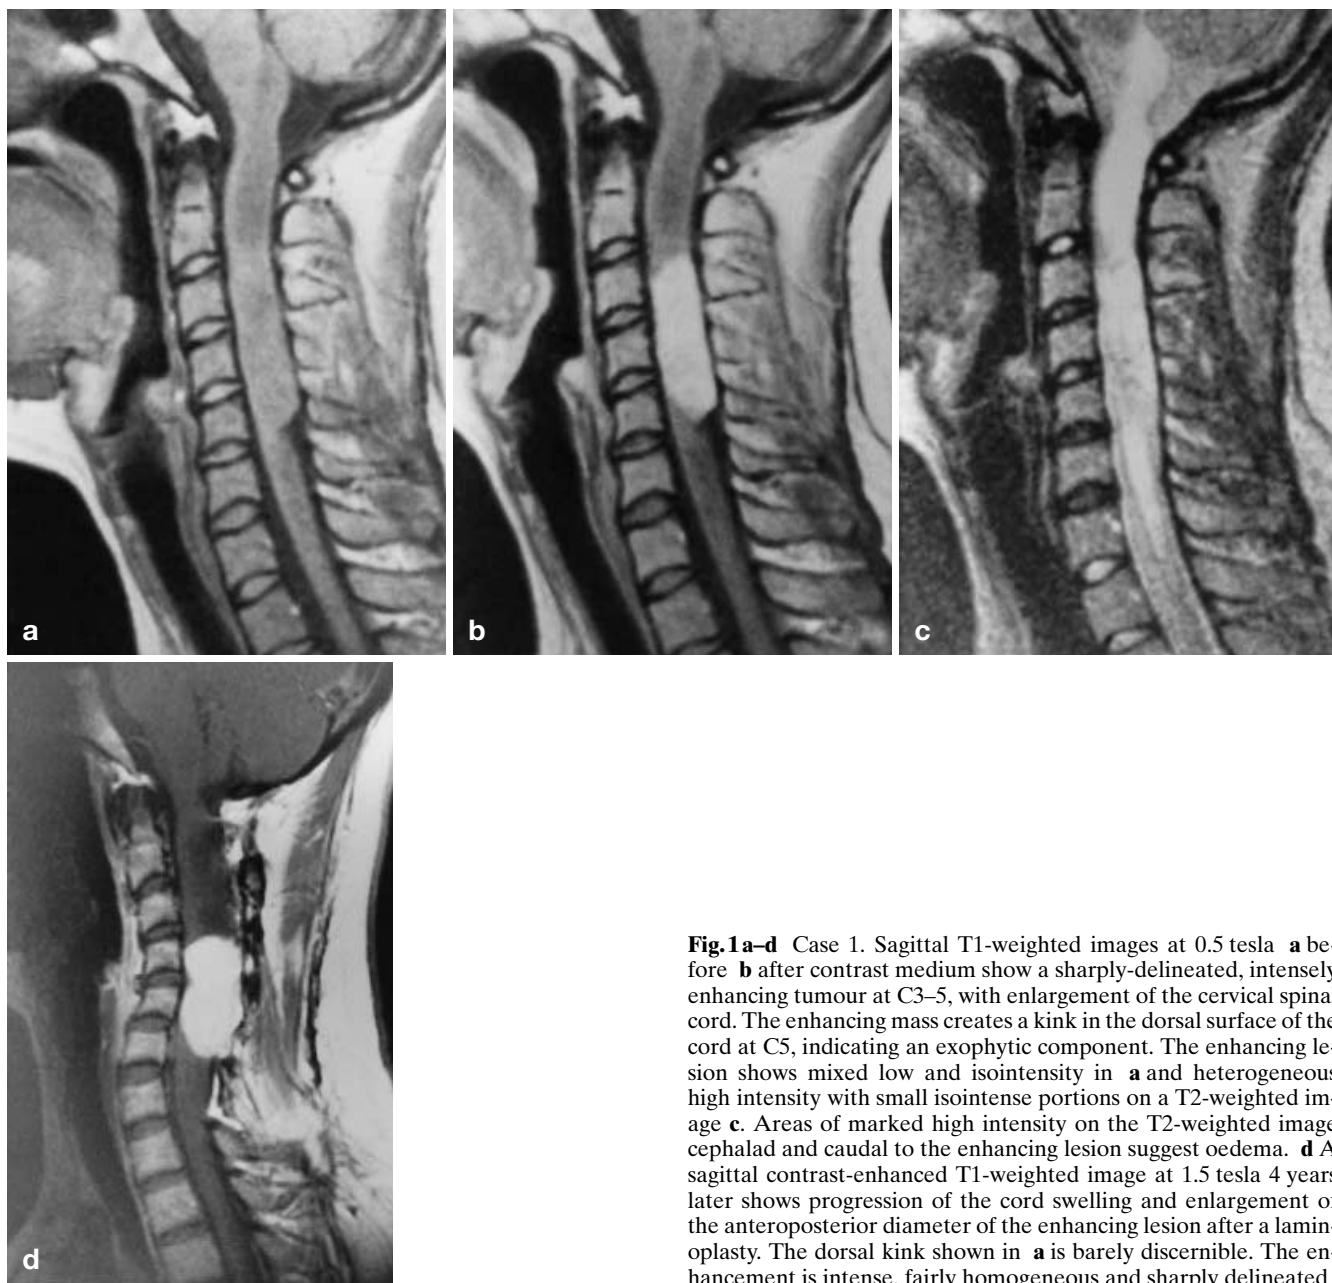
Case 1. Sagittal T1-weighted images at 0.5 tesla a before b after contrast medium show a sharply-delineated, intensely enhancing tumour at C3-5, with enlargement of the cervical spinal cord. The enhancing mass creates a kink in the dorsal surface of the cord at C5, indicating an exophytic component. The enhancing lesion shows mixed low and isointensity in a and heterogeneous high intensity with small isointense portions on a T2-weighted image c. Areas of marked high intensity on the T2-weighted image cephalad and caudal to the enhancing lesion suggest oedema. d A sagittal contrast-enhanced T1-weighted image at 1.5 tesla 4 years later shows progression of the cord swelling and enlargement of the anteroposterior diameter of the enhancing lesion after a laminoplasty. The dorsal kink shown in a is barely discernible. The enhancement is intense, fairly homogeneous and sharply delineated
